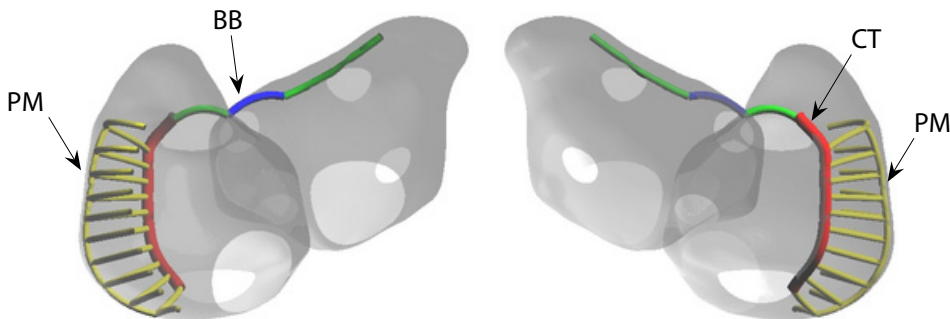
Geometry of the multilayer 3D atria showing the position of the atrial bundles: Crista terminalis (CT), pectinate muscles (PM) and Bachmann's bundle (BB). (Produced by V. Jacquemet)
